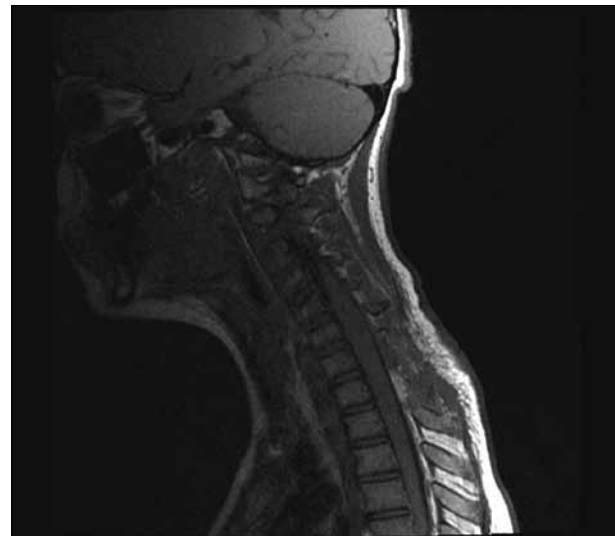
Postoperative MRI of the cervical spine
